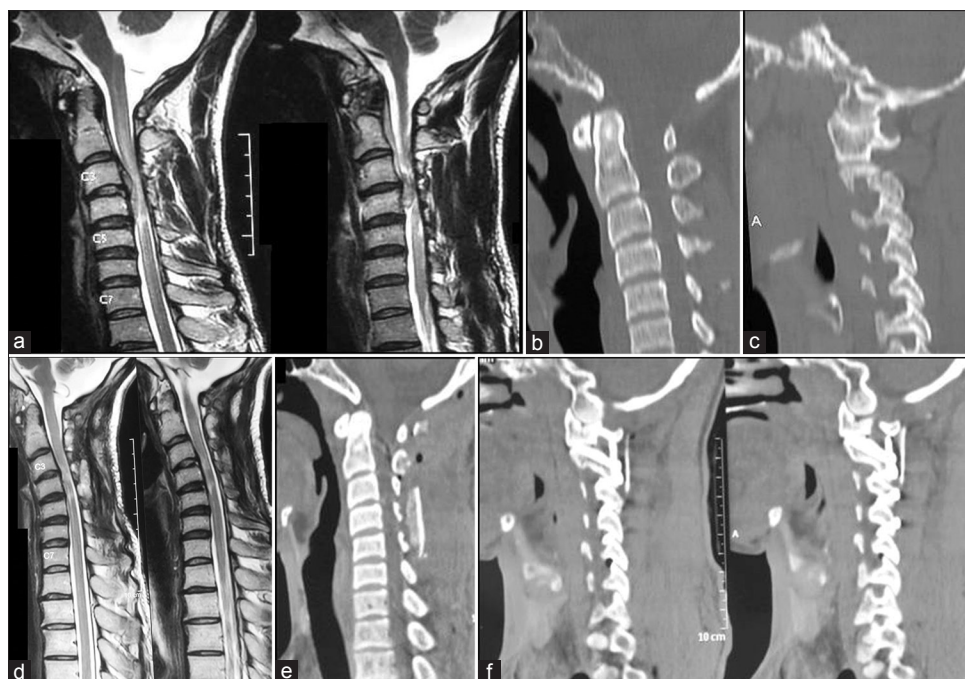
Images of a 20-year-old male patient. (a) Sagittal T2-weighted image showing a large C3-4 prolapsed intervertebral disc with cord compression. (b) Sagittal computed tomography scan. (c) Preoperative sagittal computed tomography scan with cuts passing through the facets. (d) Sagittal T2-weighted magnetic resonance imaging 3 months after surgery showing restoration of the disc space with no evidence of cord compression. (e) Postoperative sagittal computed tomography scan. (f) Postoperative computed tomography scan with cuts passing through the facets showing C1-C2 lateral mass fixation and C2- C5 transarticular fixation
